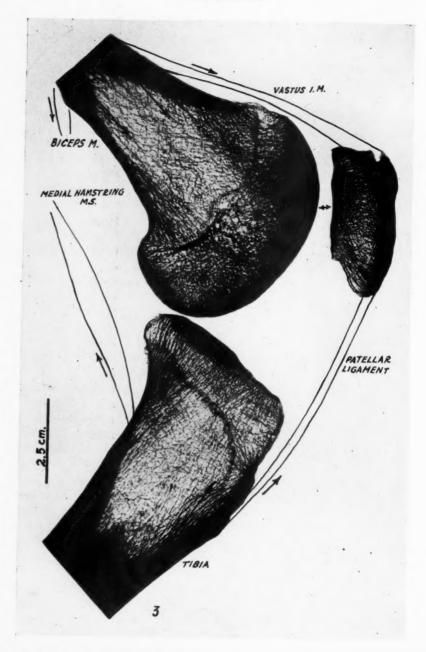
Plate III, Fig. 3. Roentgenogram of sagittal section of the human knee joint, femur, patella, and tibia. Natural size. Flexed position. The muscle forces acting on the knee joint are represented in outline. The back-pressure vectors produced by these muscles are represented by arrows within the bone structure. The direction of these arrows representing the back-pressure vectors of muscle action change with every possible position of joint range in mobilization. The dense cancellous structure produced by articulation of the patella and femur is definitely evident.
